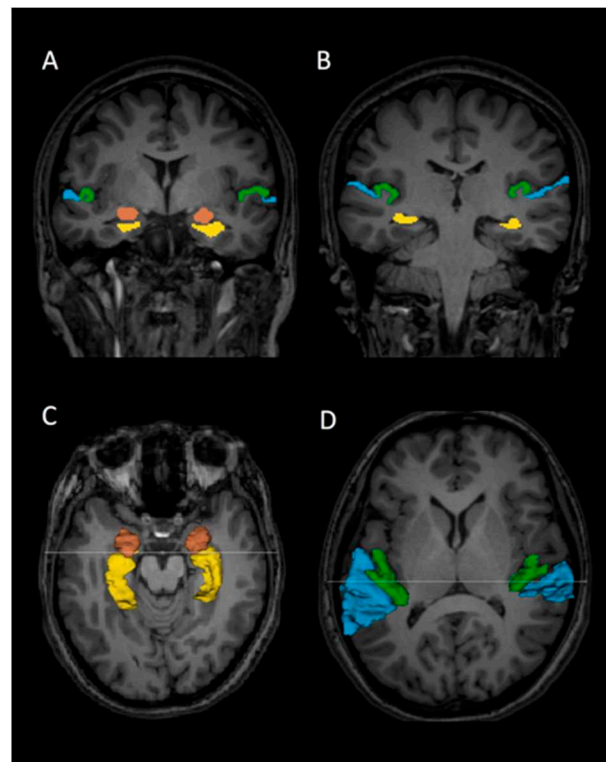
Delineation of Heschl’s gyrus (HG), planum temporale (PT), hippocampi, and amygdalae on 3 Tesla magnetic resonance imaging slices in a healthy subject. The HG (green), PT (blue), hippocampus (yellow), and amygdala (brown) regions of interest are outlined. (A,B): Coronal view of the HG, PT, hippocampi, and amygdalae. (C): Three-dimensional (3D) reconstruction of the hippocampi and amygdalae superimposed onto an axial slice. (D): 3D reconstruction of HG and PT gray matter superimposed onto an axial slice. The lines on C and D correspond to the coronal slices of A and B, respectively.
